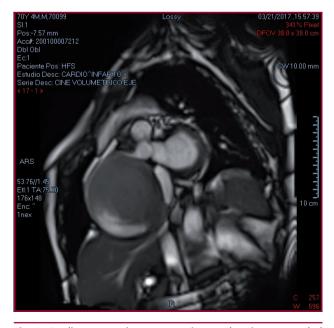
Cardiac magnetic resonance image showing a rounded image containing fluid that corresponds to the right coronary artery
